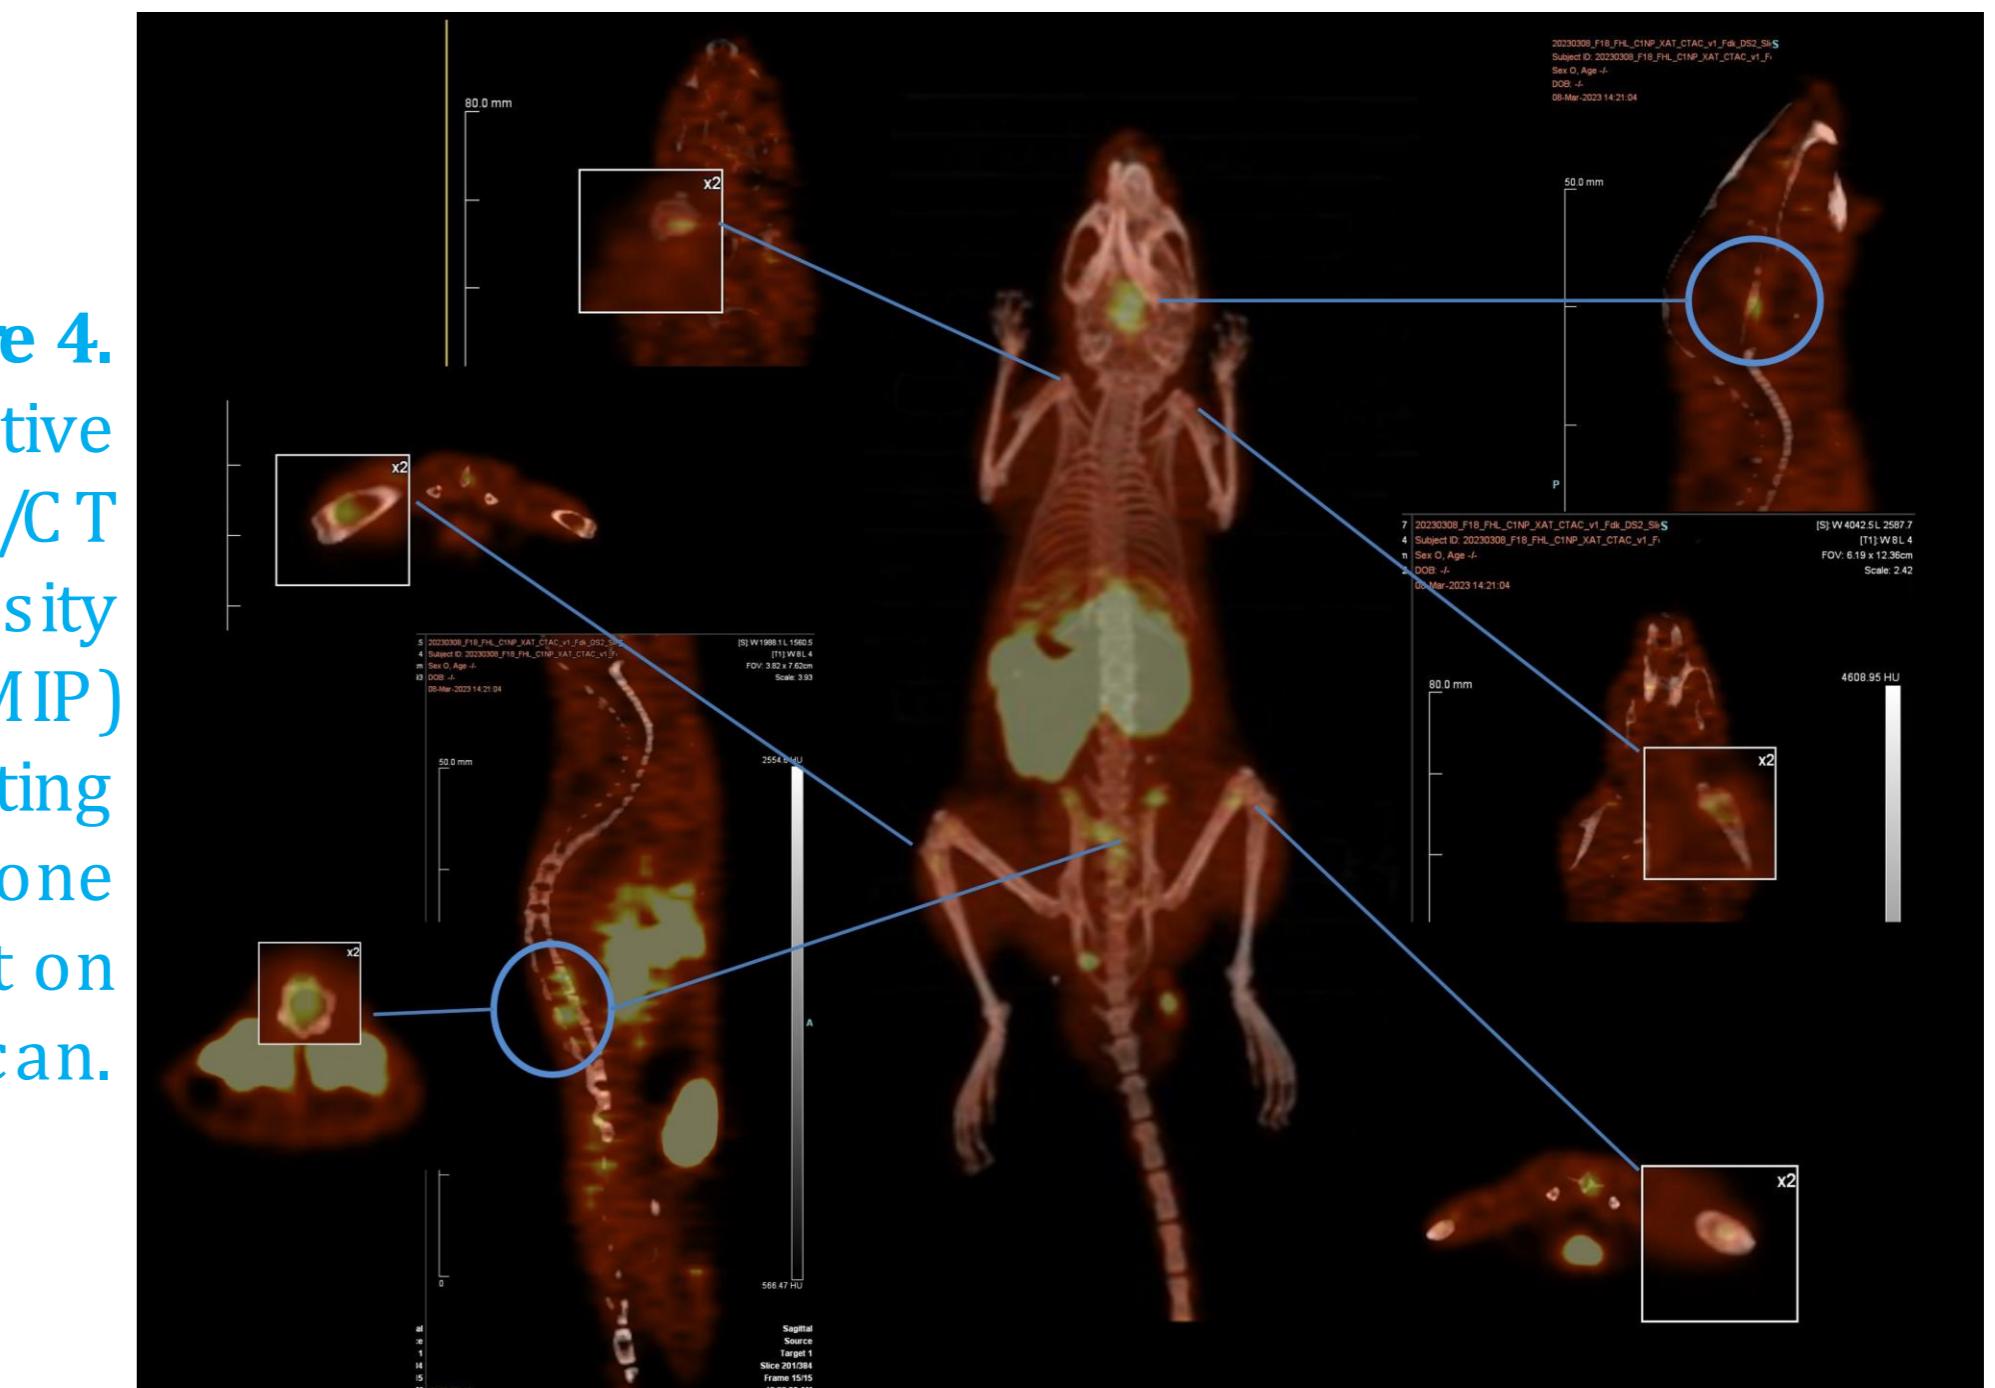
Representative [¹⁸F]FHL PET/CT maximal intensity projection (MIP) highlighting numerous bone lesions evident on the scan.
